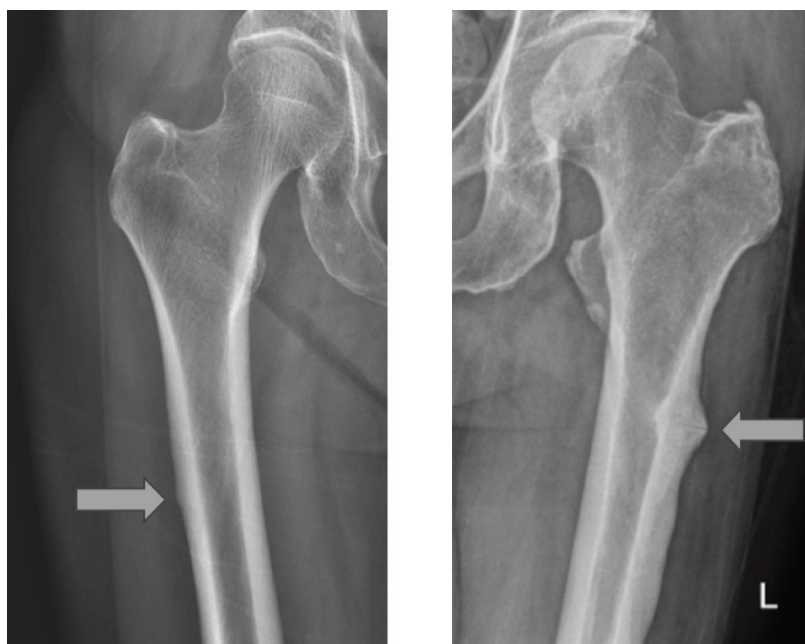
Example radiographs of cases where prophylactic nailing of the contralateral femur was (right) and was not performed (left). Grey arrows show the most prominent stress lesions on the radiographs.
